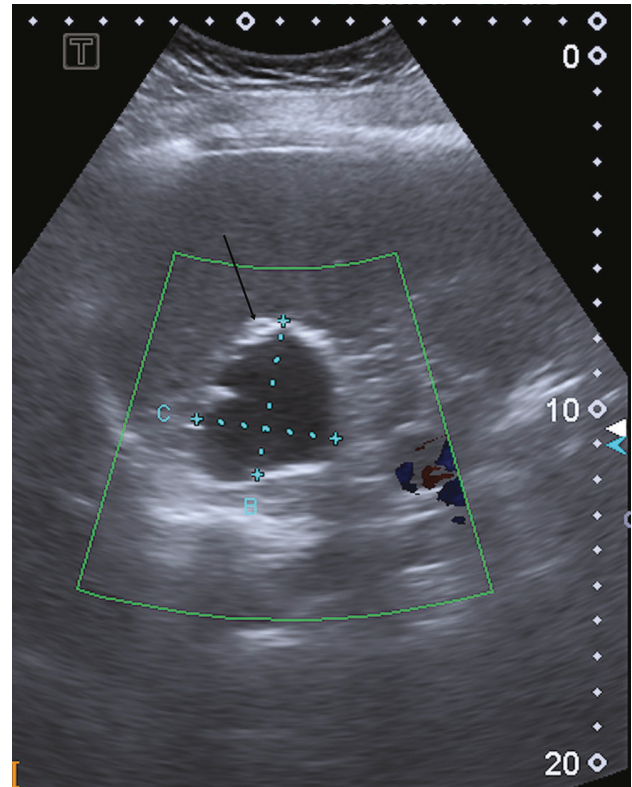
Abdominal ultrasound in a 58-year-old asymptomatic woman from the province of Entre Ríos shows a focal anechoic lesion of echogenic margins consistent with calcifications (arrow), located in the liver parenchyma. Gharbi type V-CE5.
